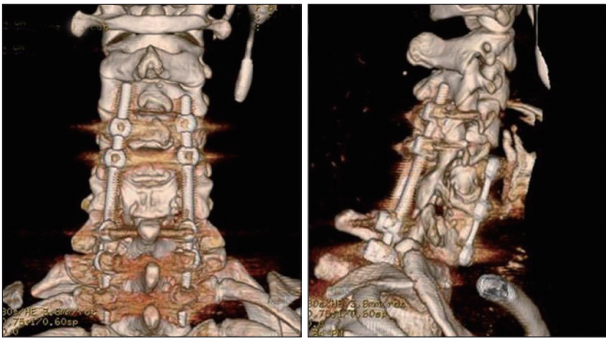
Post-operative three-dimensional reconstruction computed tomography scan of the cervical spine.
